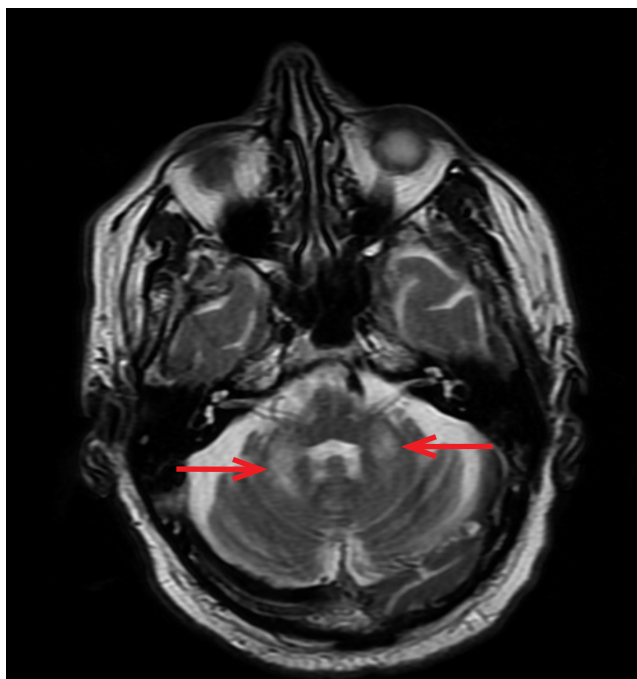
Symmetrical foci of high signal in the T2-weighted images at the level of the middle cerebellar peduncles.
